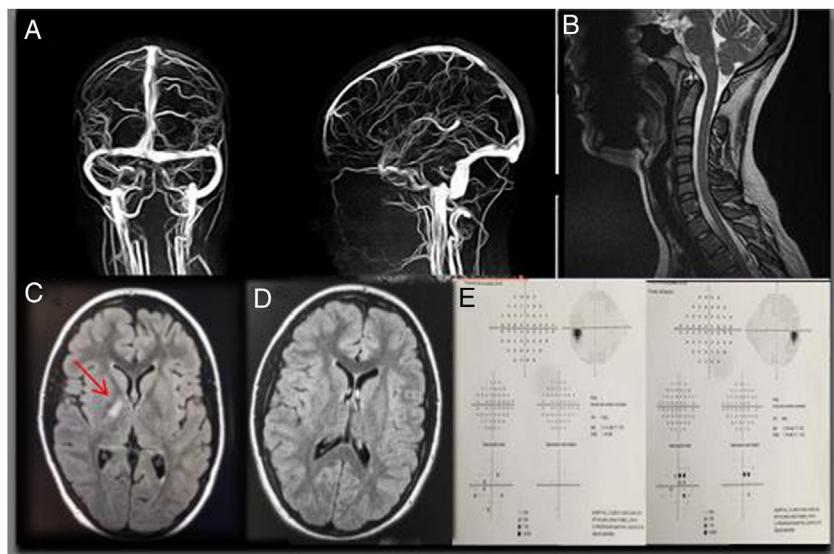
Supplementary tests of patient 1 (CPG) (A) angio-MRI images without alterations. (B) MRI with gadolinium of cervical spinal column without alterations. (C) axial MRI image in FLAIR sequence with gadolinium showing hyperintense lesions in the capsulo-thalamic region suggesting demyelinizing disease. (D) MRI taken 6 months after the first, showing absence of lesions. (E) Humphrey 24-2 campimetry within normal ranges in both eyes (minimum paracentral defect in LE).
